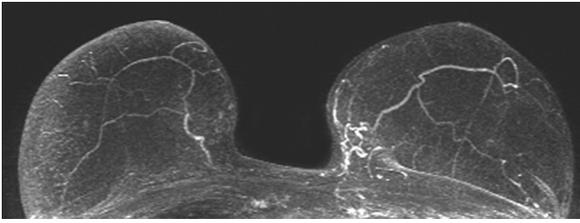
Normal findings. Short first-pass MRI of the breast. Normal findings on MIP-technique acquired after a total measurement time of 4:35 min
